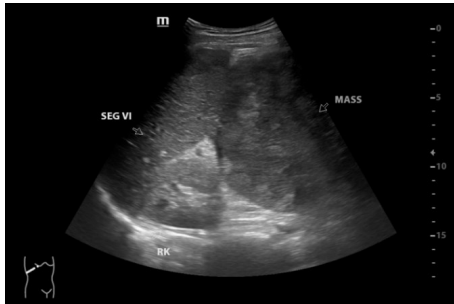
Ultrasound image showing the mass as an intraperitoneal mass which was compressing onto and closely attached to the right liver lobe.
